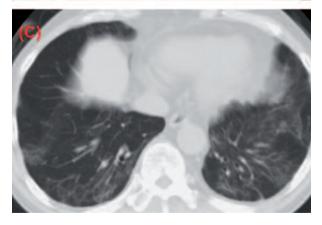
Chest radiograph on admission (A) showed reticular shadows in the bilateral lung fields, and chest CT on admission (B, C) showed ground-glass opacities and curvilinear shadows in the bilateral dorsal lower lung fields.
